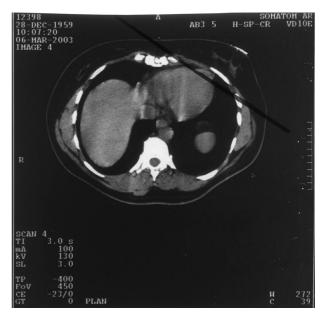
CT scan of the lower part of the irradiated field
